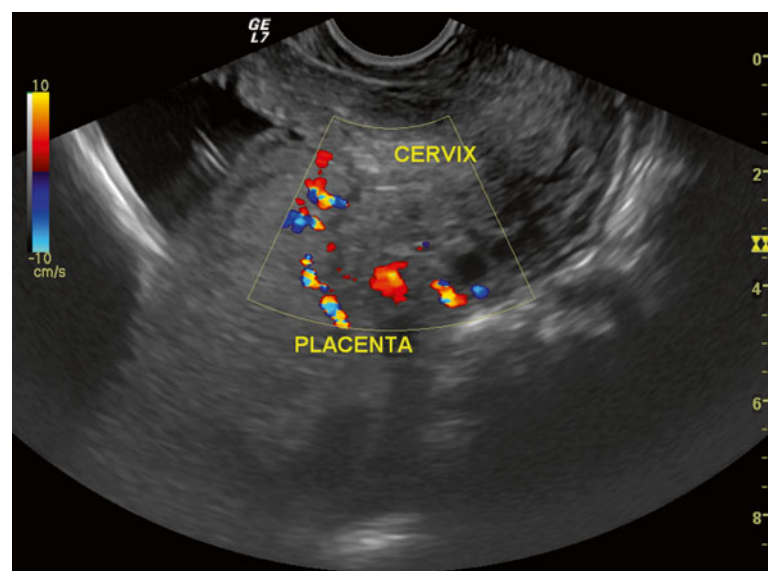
An ultrasonographic image showing a central placenta previa after ART
